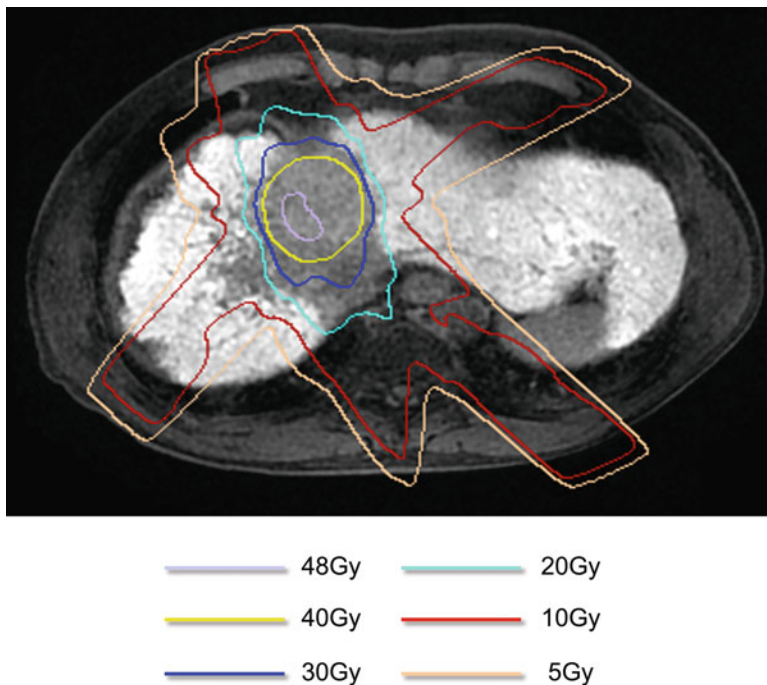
The EOB-MRI at hepatobiliary phase 6 months after SBRT. The signal intensity of the irradiated liver parenchyma exceed 30 Gy is low
